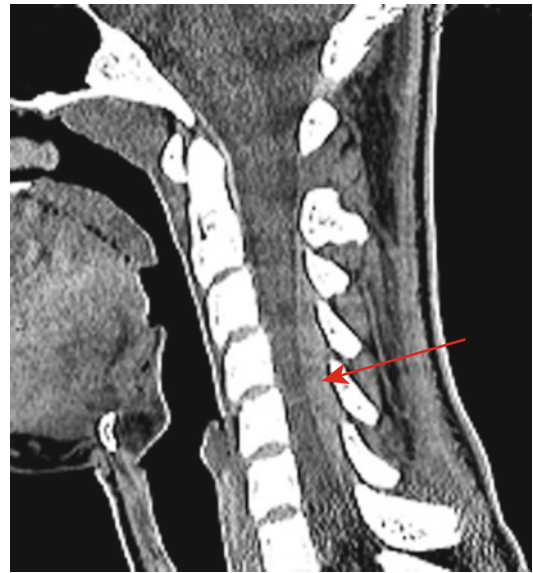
MRI showing cord compression with epidural bleeding
